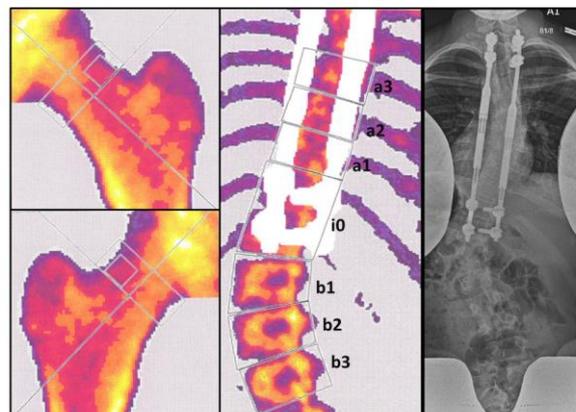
Areal bone mineral density (aBMD) measurements prior to spinal fusion surgery in a 14-year-old girl diagnosed with juvenile idiopathic scoliosis and treated with magnetically controlled growing rods. To the left: aBMD of left and right total hip; Middle: aBMD of the spine with the zones of interest. Mean aBMD of vertebrae within the instrumentation (zone a1-3) was $0.676 \text{ g}/\text{cm}^2$ and aBMD of vertebrae below the instrumentation (zone b1-3) was $0.795 \text{ g}/\text{cm}^2$; To the right: Anterior-posterior radiograph at the time of examination showing a major curve of 40 degrees.
